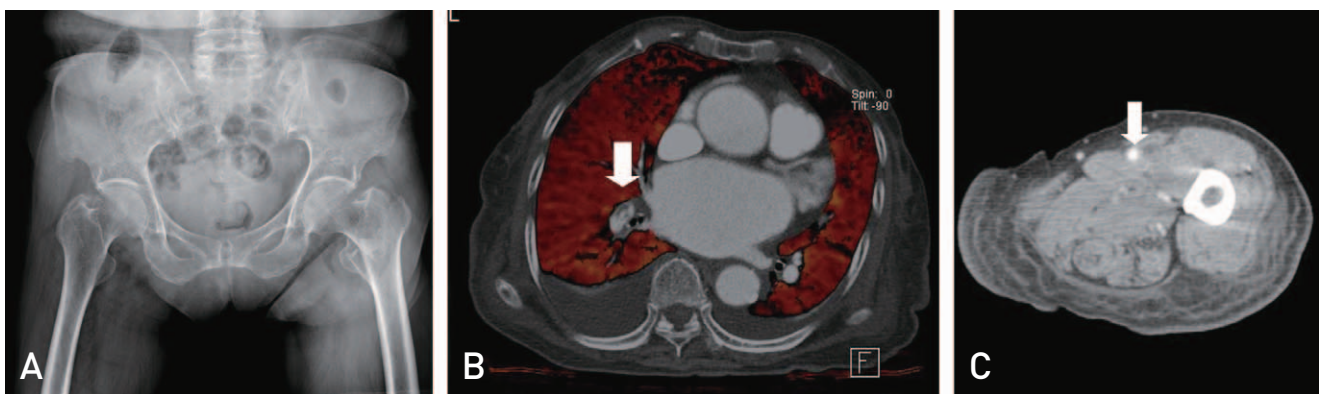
Both pulmonary embolism and deep vein thrombosis were observed on indirect multidetector computed tomographic venography preoperatively in an 89-year-old female patient with intertrochanteric femoral fracture.
